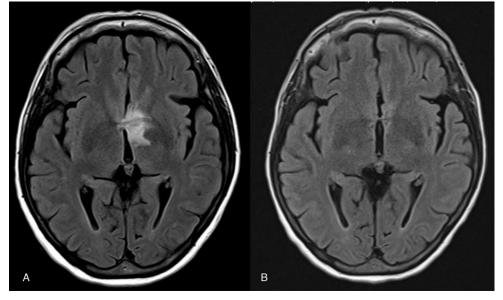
A) MRI Prior to treatment B) MRI post systemic chemotherapy showing resolution of the hypothalamic lesion
